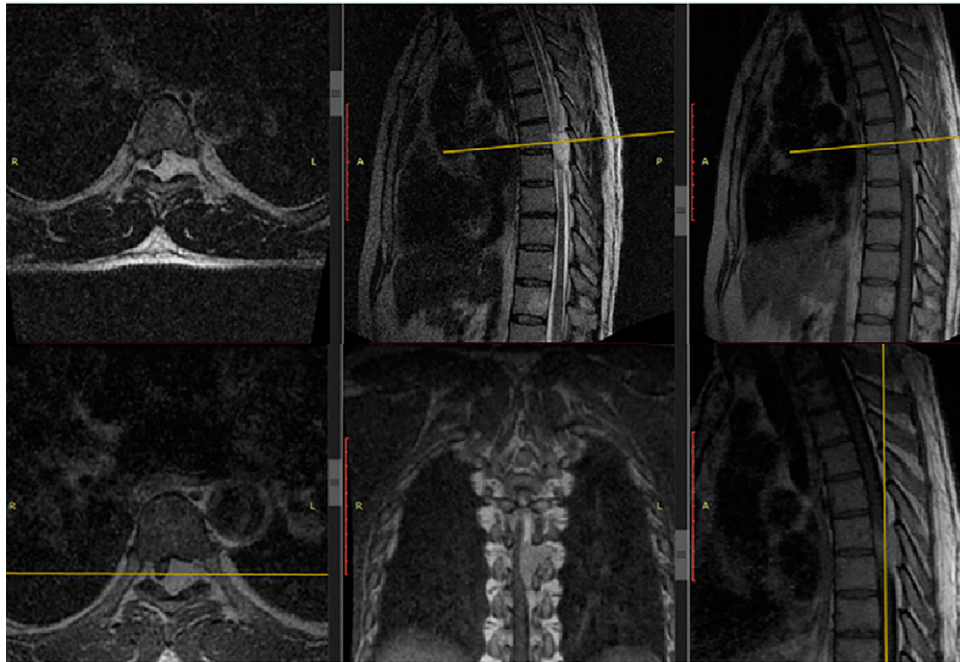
MRI sequence of a midthoracic (T6–7) epidural mass that is hyperintense to both T1 and T2 with postcontrast enhancement.
